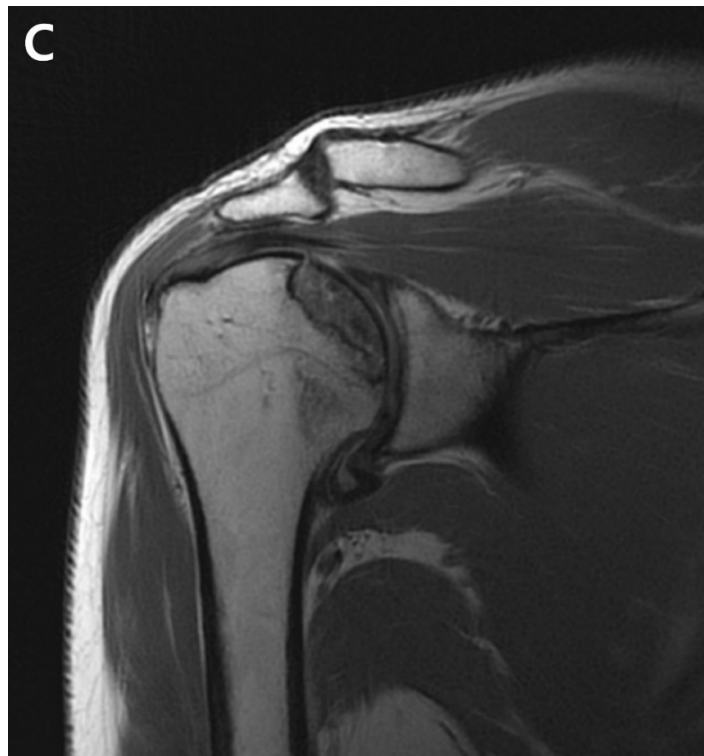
(A). Postoperative plain radiograph obtained 21 months post-ACR. (B). Oblique coronal T1 fat-suppressed MRI. (C). Oblique coronal T2 fat-suppressed MRI shows osteolytic changes in the superomedial humeral head. MRI shows cystic changes in the epiphyseal area, but articular congruity remains preserved.
